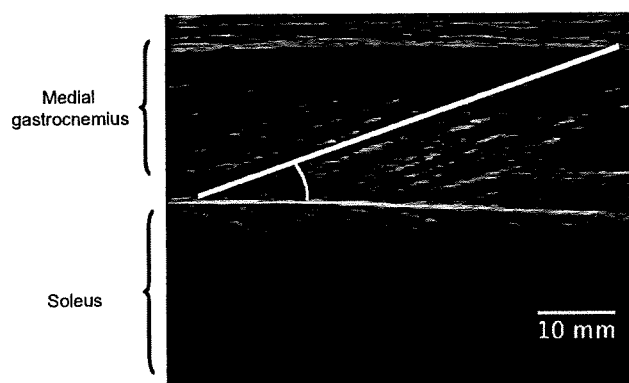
An example of ultrasound image taken during static action. Fascicle lengths and pennation angles of MG were measured as shown in the image.
